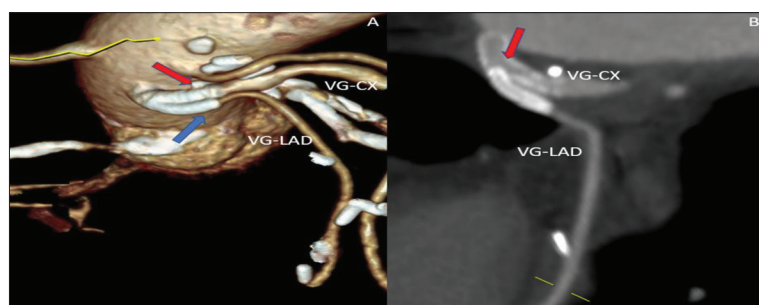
A) CT coronary angiography – 3D reconstruction of the aorta and implanted stents in the Y graft; the red arrow points towards the stent implanted in the vein graft (VG) for ramus circumflex artery (RCX), while the blue arrow points towards the stent implanted in the VG for left anterior descending artery (LAD); B) both patent stents and VGs; the red arrow points towards the area of neo carina
